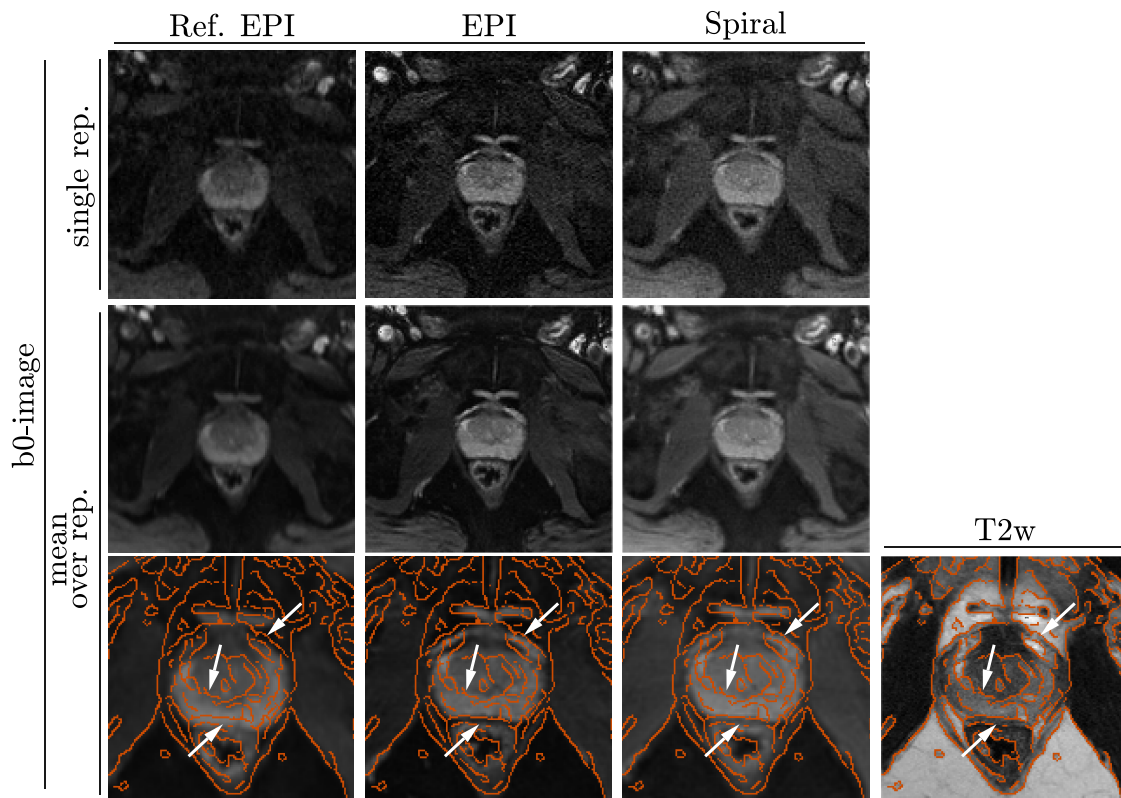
Qualitative evaluation of dMRI images acquired and reconstructed using different methods. A single $b = 0 \text{ ms}/\mu\text{m}^2$ image (1st in each series of acquisition) from a patient imaged with three PGSE sequences: the vendor’s EPI-sequence and prototype sequence with EPI and spiral readout (*top row*). Average $b = 0 \text{ ms}/\mu\text{m}^2$ from three protocols (*middle row*), zoomed in and with overlaid edges detected on T2-weighted image (*bottom row*). The improved alignment of fine anatomical features across modalities is highlighted with white arrows.
